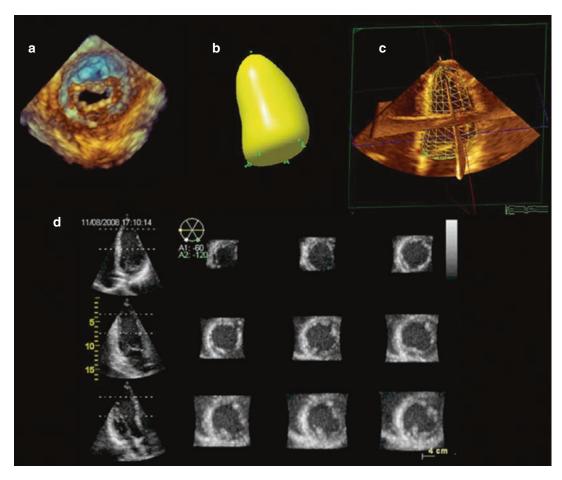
Three-dimensional echocardiographic images presented in four broad categories: (a) volume rendered, (b) surface rendered, (c) wireframed and (d) 2D tomographic slices [8]
